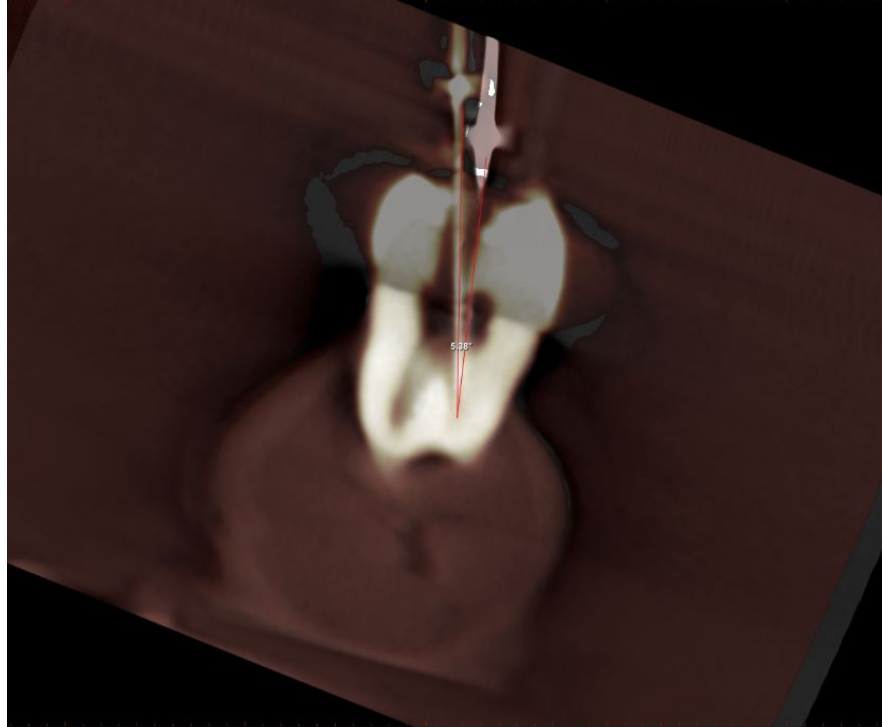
Overlapped CBCT scans in coronal view of file in place in both tooth with and without crown present.
